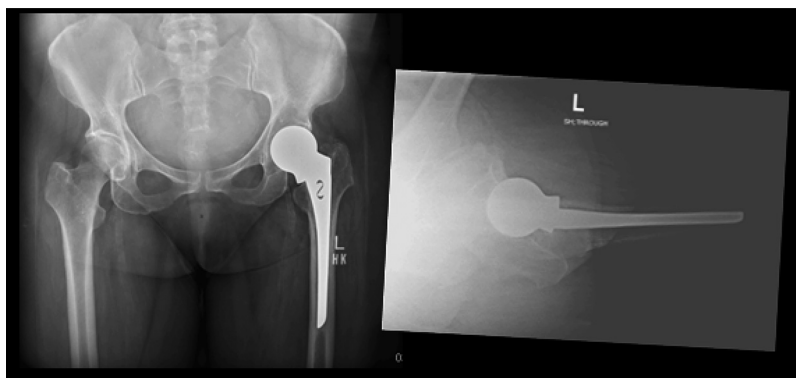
Preoperative radiograph showing the Uncemented Hemiarthroplasty with no obvious lysis or loosening of hip prosthesis.
